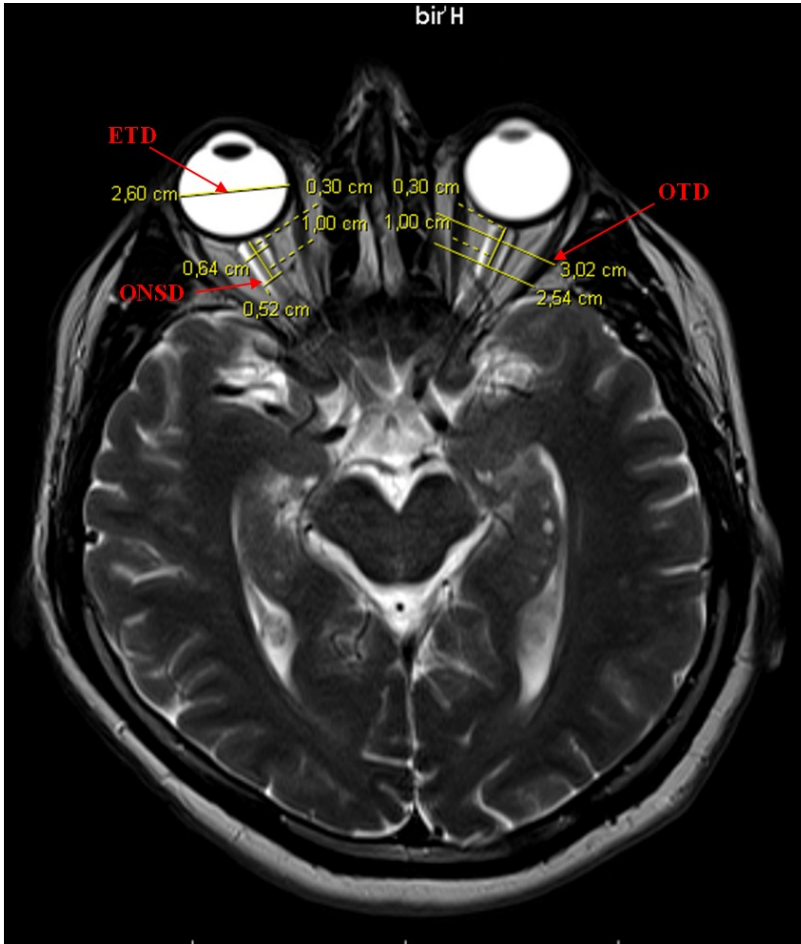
Axial T2W magnetic resonance imaging of the both orbit demonstrating the measurement techniques: On the left side, OTD (medial orbital wall to lateral orbital wall); on the right side, ETD (retina to retina) and ONSDs measurements 3 mm and 10 mm behind the globe were showed.
